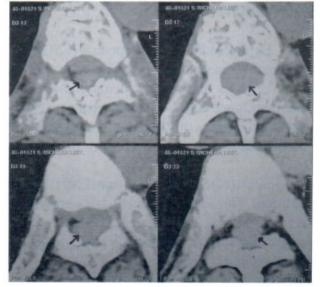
Axial non-contrast enhancement CT scan shows the mass causing compression and anterior displacement of the spinal cord.
